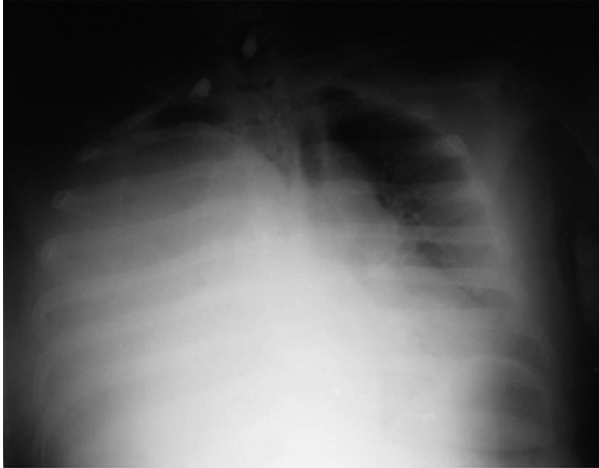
Chest X-ray study reveals opaque right hemithorax and mediastinal shift with tracheal displacement.
